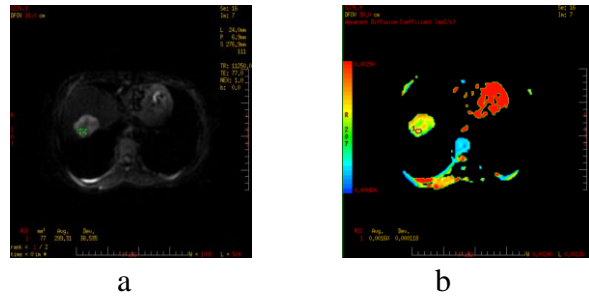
a) The axial DWI image showing hemangioma lesion with diffusion restriction, b) ADC of the same with ADC value as : $1.6 \times 10^{-3} \text{ mm}^2/\text{sec}$.
